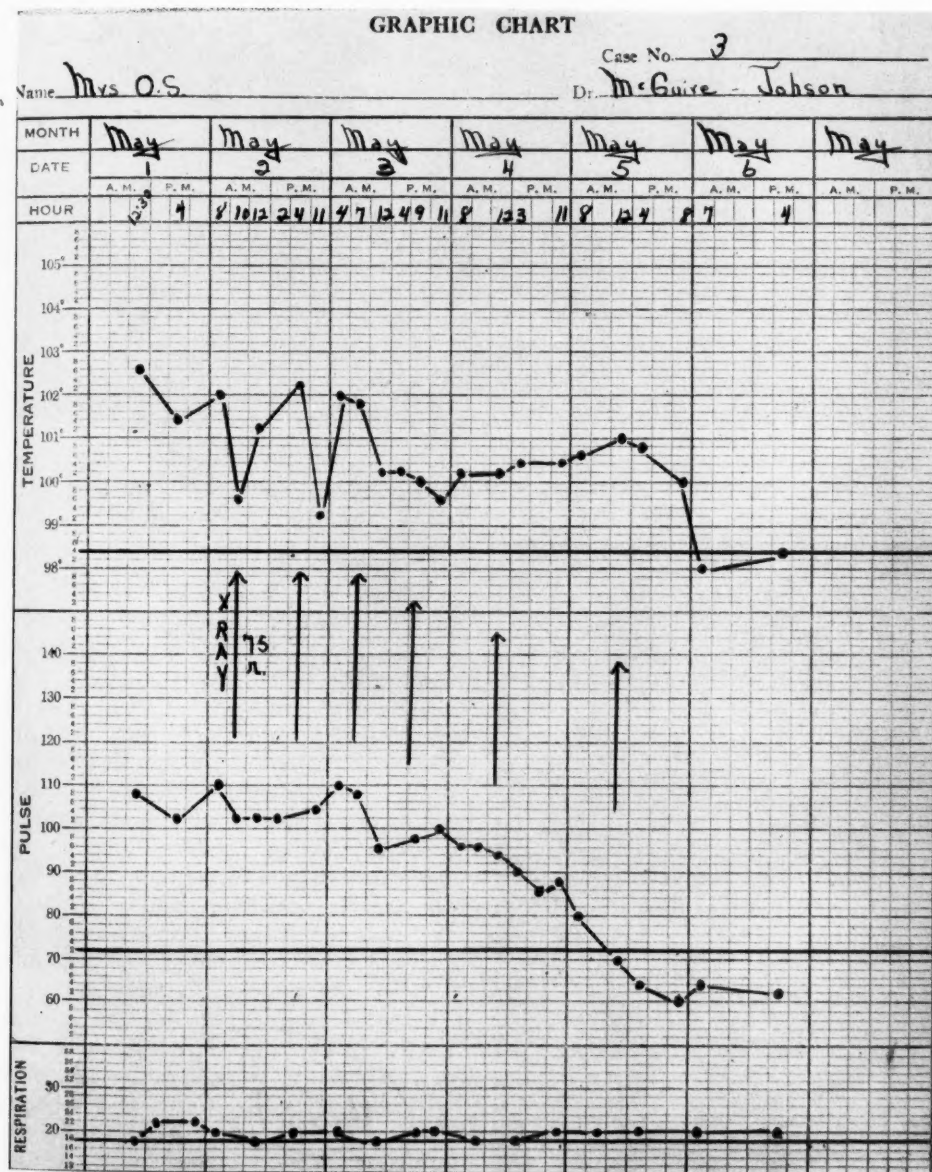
Case 3. Diagnosis: peritonitis. X-ray technic: 100 kv.; ma. 5; distance 40 cm.; filter 2 mm. Al; r units, 80 per treatment; port, abdomen; result, excellent.
